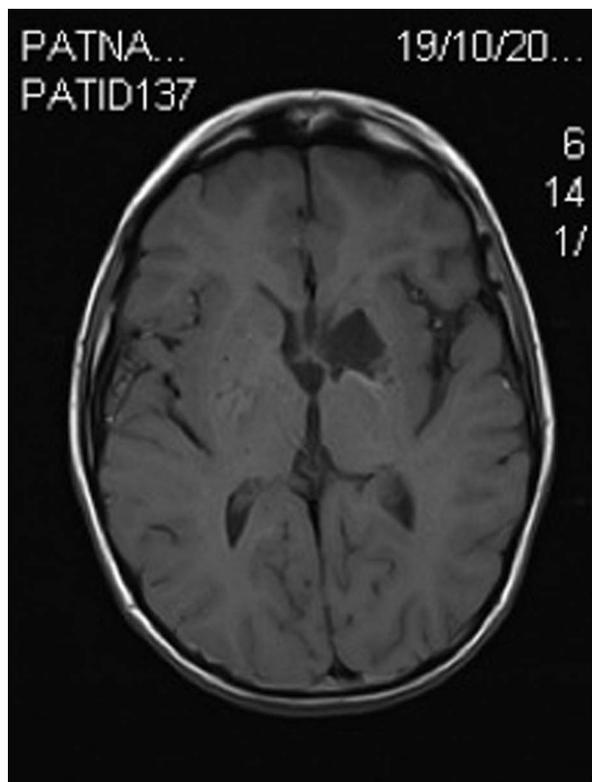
MRI showing a hypodense lesion in the region of the left globus pallidus.
